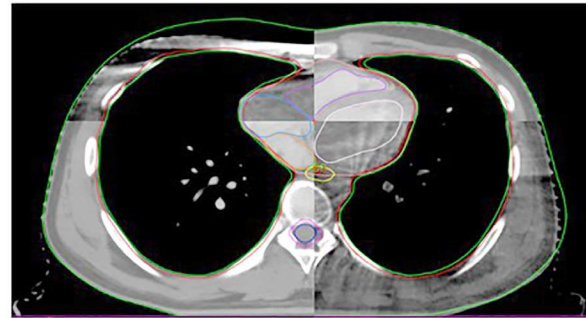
Daily CBCT reconstruction Image
